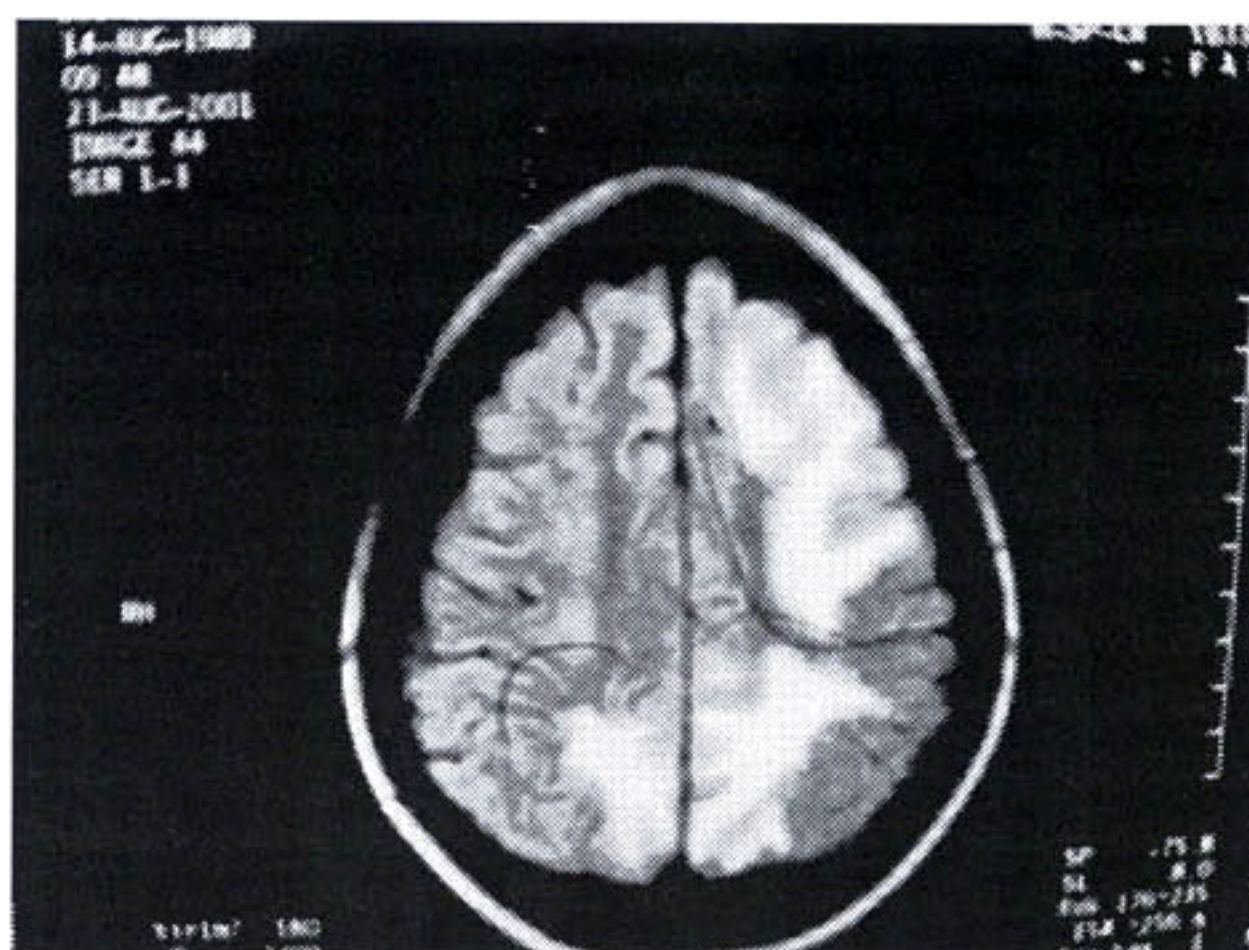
Magnetic resonance image of brain revealing multiple deep white matter hypodensities with areas of edema
